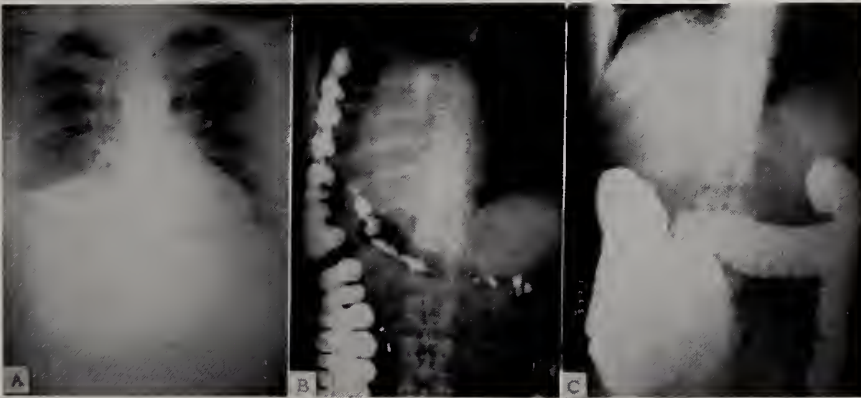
A, B—Large, traumatic right diaphragmatic hernia with part of liver, ascending and transverse colon in right chest. C—Postoperative x-ray showing colon back in normal position.
